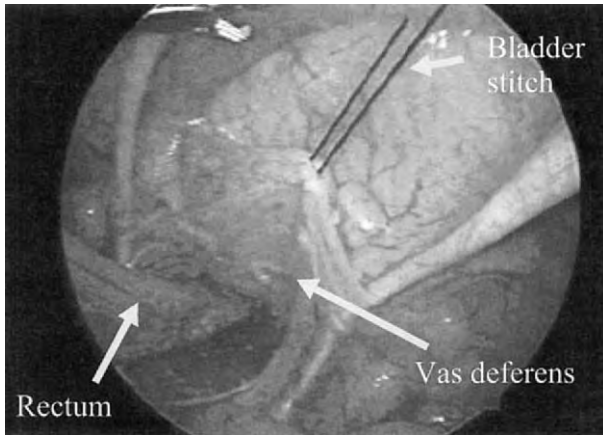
Although decompressed, the floppy bladder still needs to be retracted anteriorly. In this figure, a percutaneously placed U-stitch is placed through the bladder and is used for retraction, thereby allowing exposure of the deep pelvic structures. (From Sydorak RM, Albanese CT: Laparoscopic repair of high imperforate anus. *Semin Pediatr Surg* 11:217-225, 2002.)
